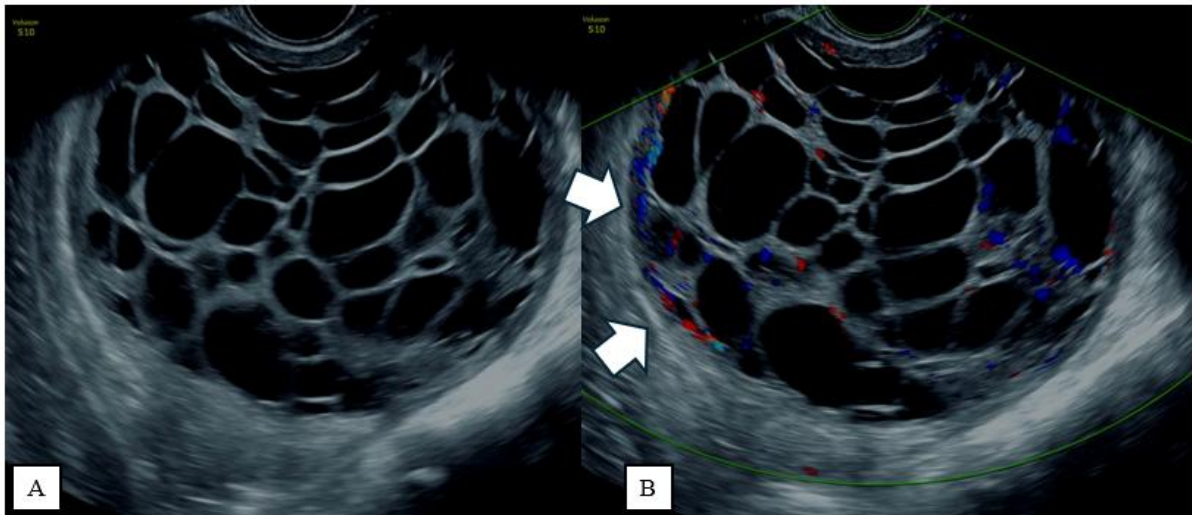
Endovaginal ultrasound.
